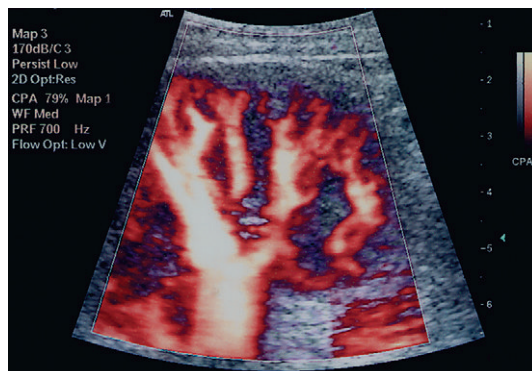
Colour power Doppler demonstrating perfusion of the renal parenchyma.
